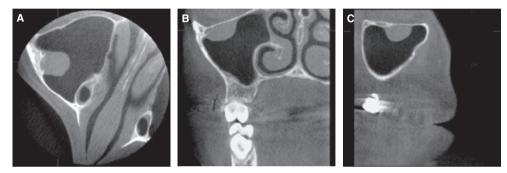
Representative cone-beam computed tomography scans of a polypoid mucosal thickening in a 10-year-old male patient: (A) axial scan; (B) coronal scan; and (C) sagittal scan.
